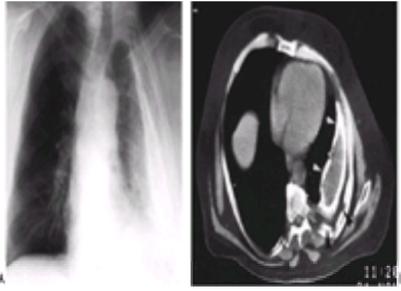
A: A chest radiograph depicts a relatively small left hemithorax, pleural thickening, and extensive pleural calcification. B: Subsequent chest CT reveals calcification of the visceral (*white arrowheads*) and parietal pleura surrounding a high-density pleural effusion. The apparent pleural thickening on the chest radiograph is shown to be extensive subpleural fat (*black arrowheads*). Increased asymmetric subpleural fat associated with a pleural effusion is almost always indicative of an empyema, in this case a tuberculous empyema.
